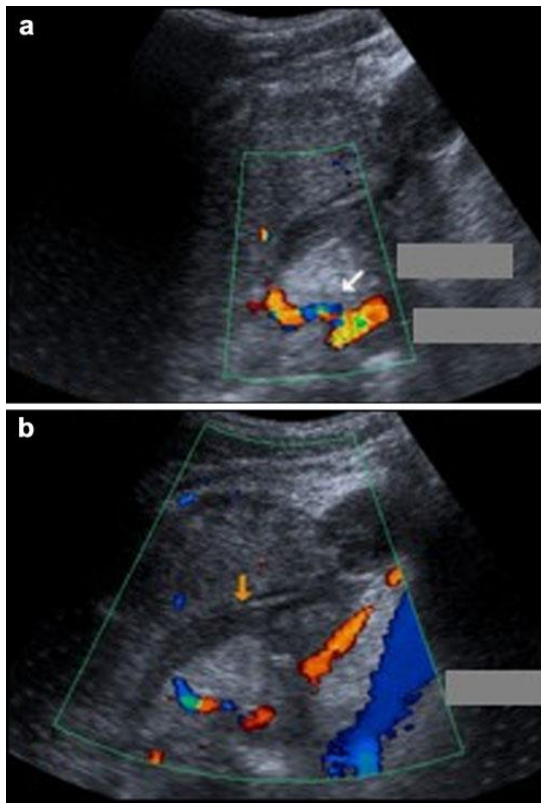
A 37-year-old man after SPK transplantation, with persistent amylase elevation. Abdominal ultrasound-Doppler performed 2 weeks after transplantation shows the iliac arteries and the graft's arterial vessels (a arrow) permeable but with aliasing and high resistive index (RI). The iliac vein showed normal flow. However, no flow was detected at the graft's portal vein, suggesting thrombosis (b arrow). At surgery, thrombosis was confirmed and pancreatectomy was performed
